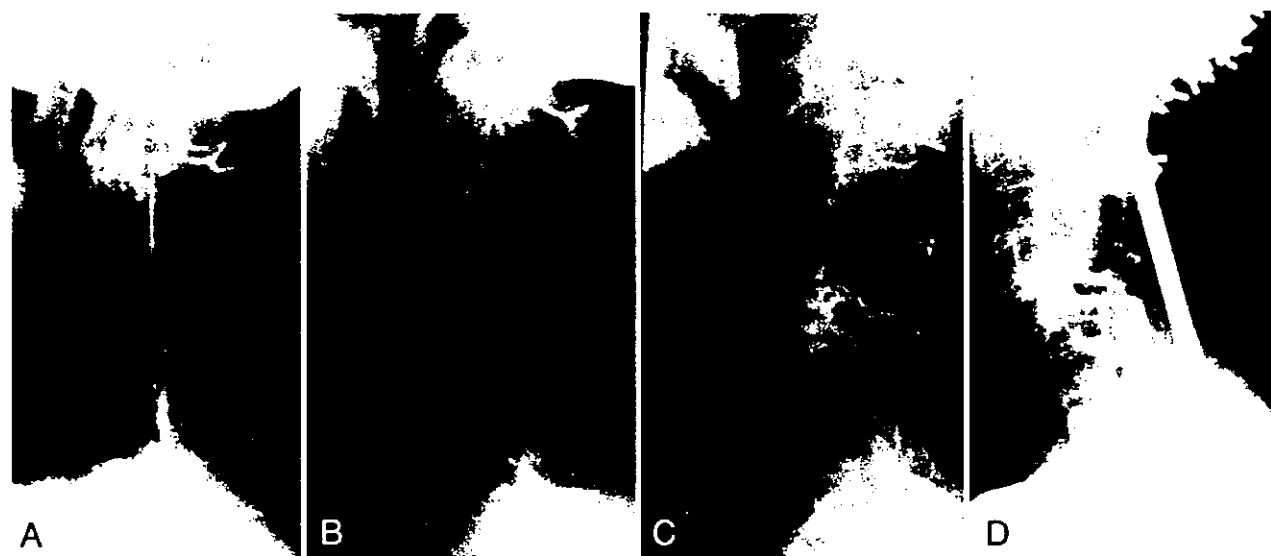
Lateral radiographs obtained in a 46-year-old woman with mutilating-type RA. A: Preoperative radiograph revealing vertebral slippage at C3-4 in flexion. B: The patient underwent laminoplasty and myelopathy improved from Ranawat Class IIIA to Class II. C: Four years postoperatively, new development of slippage occurred at C4-5 followed by collapse of the C-4 vertebral body. Myelopathy deteriorated to Class IIIB. D: Posterior instrumentation-augmented occiput-T4 fusion was performed. Iliac bone graft was added throughout the instrumentation area. The patient became ambulatory after reoperation.
